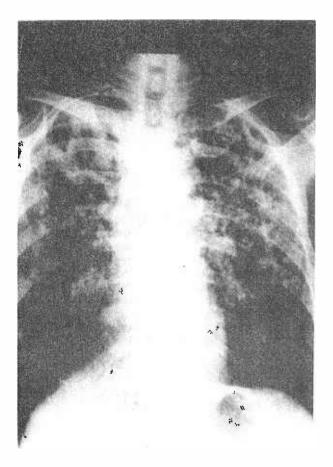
The Chest radiograph of Case 2 showing bilateral active Koch's lesion.
